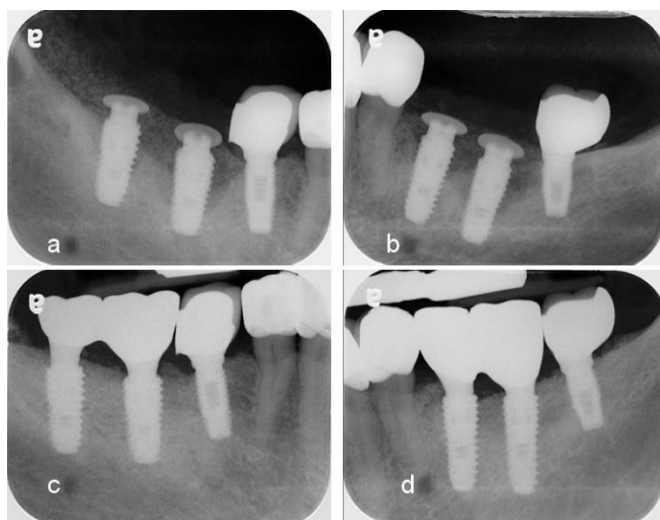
A postoperative plain radiograph on the right ridge
